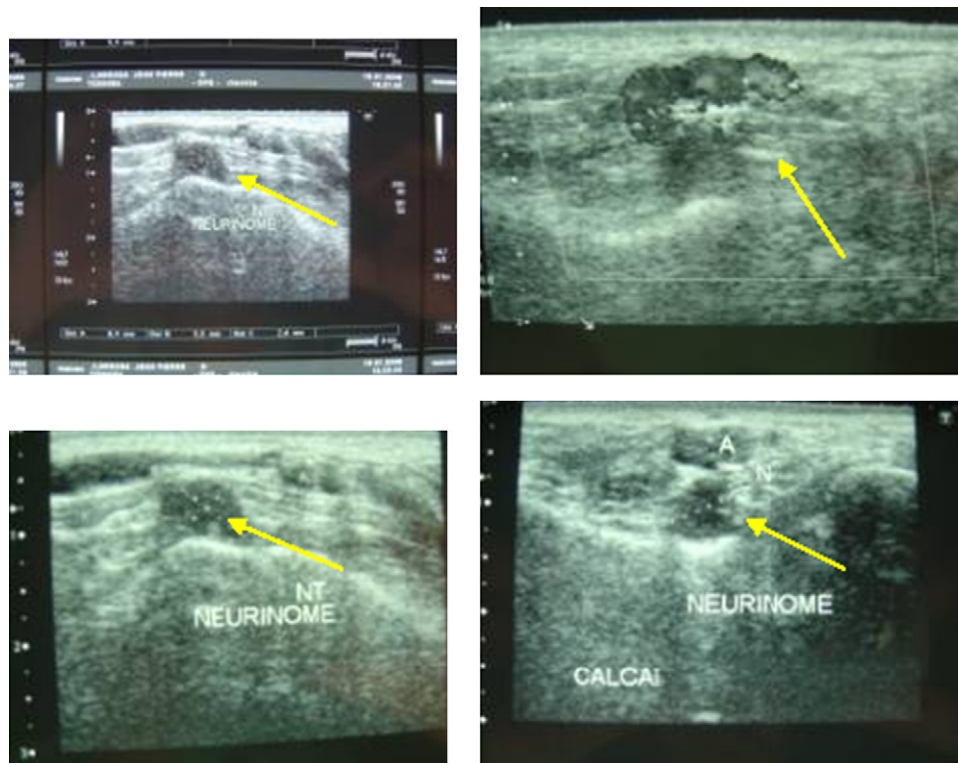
Ultrasound demonstrating a hypoechogenic area, the diagnosis presumed was a neurilemoma.
